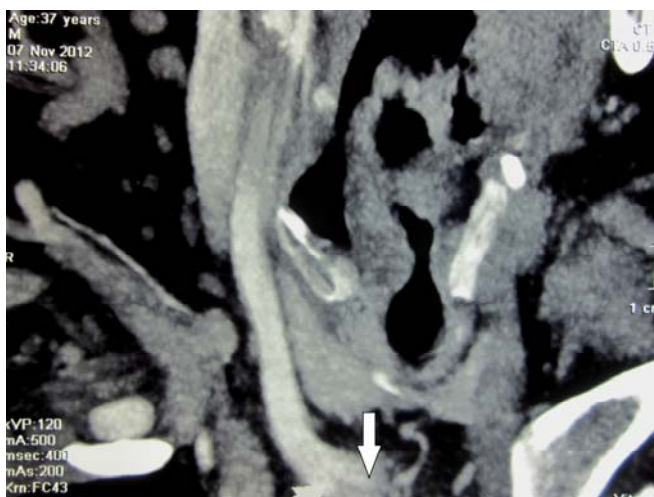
Multislice computed tomography (MSCT) angiography of carotid arteries shows dissection of the common carotid artery with subtotal prebulbar stenosis (arrows) and right internal carotid artery non-significant calcified stenosis.
